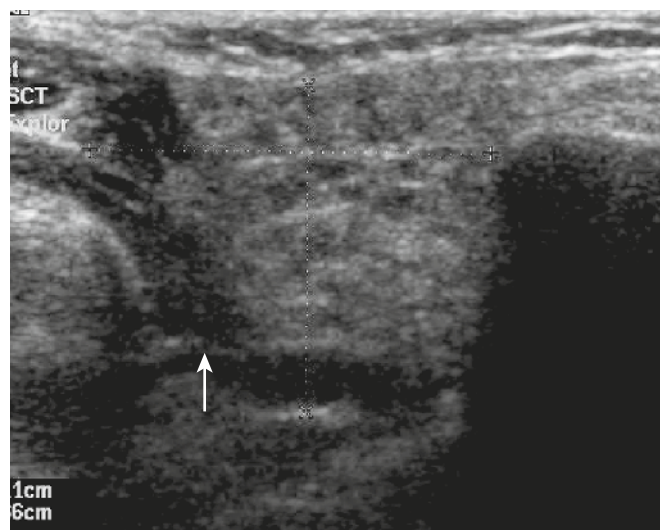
In the transverse parotid gland scan, the transverse facial artery is visible without color Doppler (*arrow*). Notice the heterogeneous aspect of the gland.
